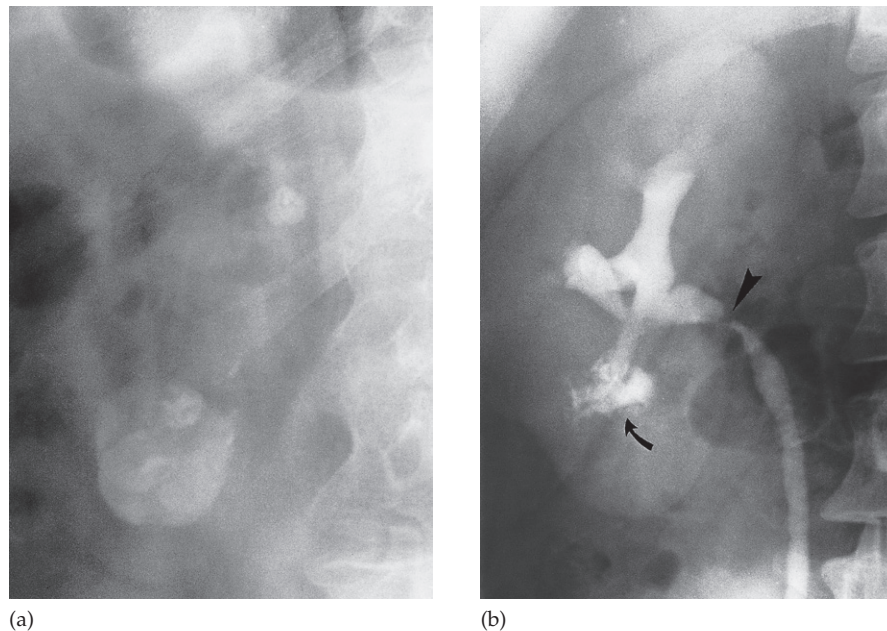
(a) Renal parenchymal calcification from tuberculosis on plain film. (b) In another patient, after contrast, there is irregularity of the calices (curved arrow) and stricture formation of the pelvis (arrowhead).
